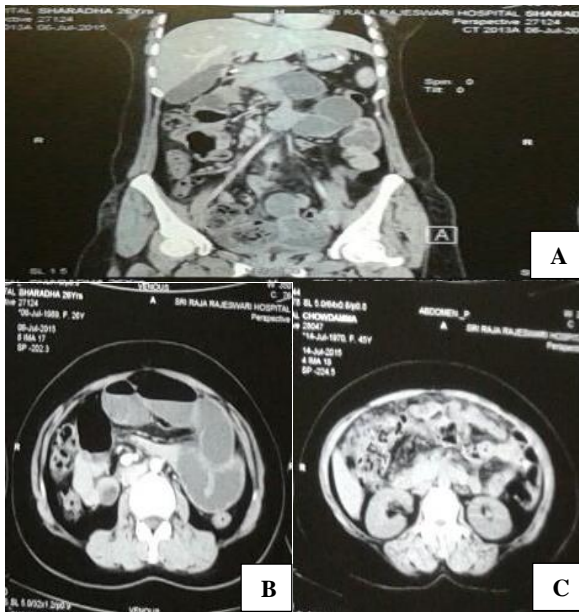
CT Abdomen showing suspension of diverticulosis in the ileum.
